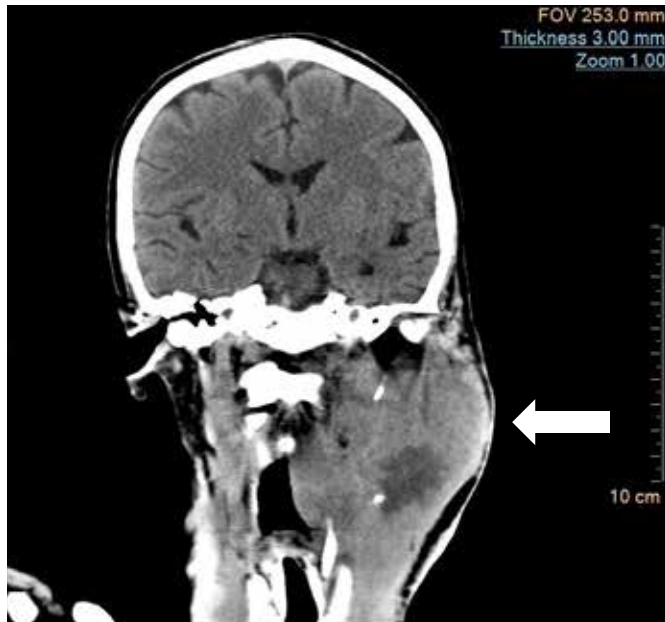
Sagittal CT image showing a large heterogeneous soft tissue neck mass (white arrow)
